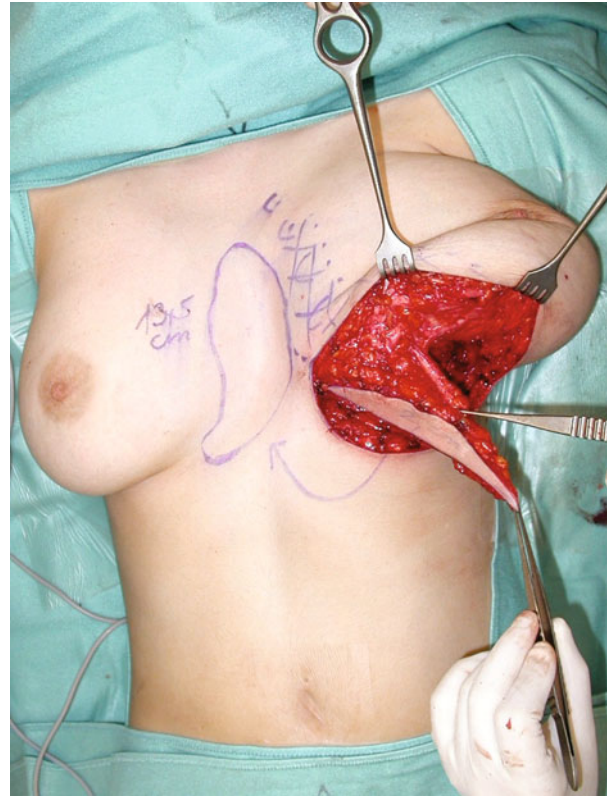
The pedicled adipo-dermal flap is based on parasternal perforator vessels (indicated by tip of forceps), then de-epithelialized and transposed into a subcutaneous pocket at the presternal funnel. Further surplus tissue of the hyperplastic breast was resected as a discoid from the breast base, resulting in an inconspicuous single scar at the inframammary crease
